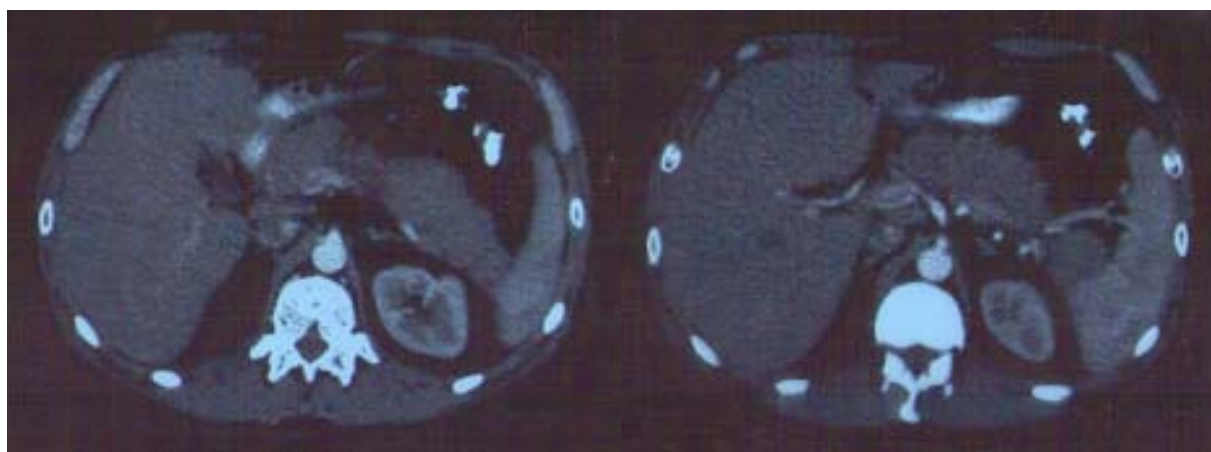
Type 2 autoimmune pancreas: multislice computed tomography (enlarged, hypodense pancreas bordered by a thin capsule, "sausage-like pancreas" and a smaller amount of ascites).
